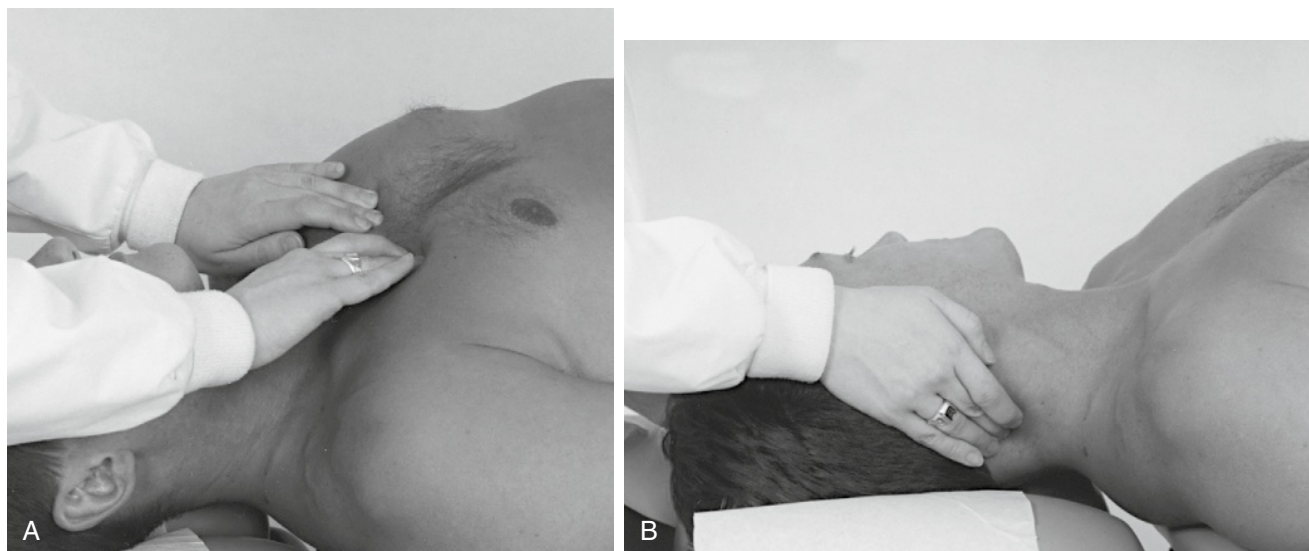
Treatment of Chapman (neurolymphatic) reflex for sinus involvement, using rapid circular massage over anterior reflex located between the second and third intercostal spaces parasternally (A) and posterior reflex located over the lamina of C2 (B).
